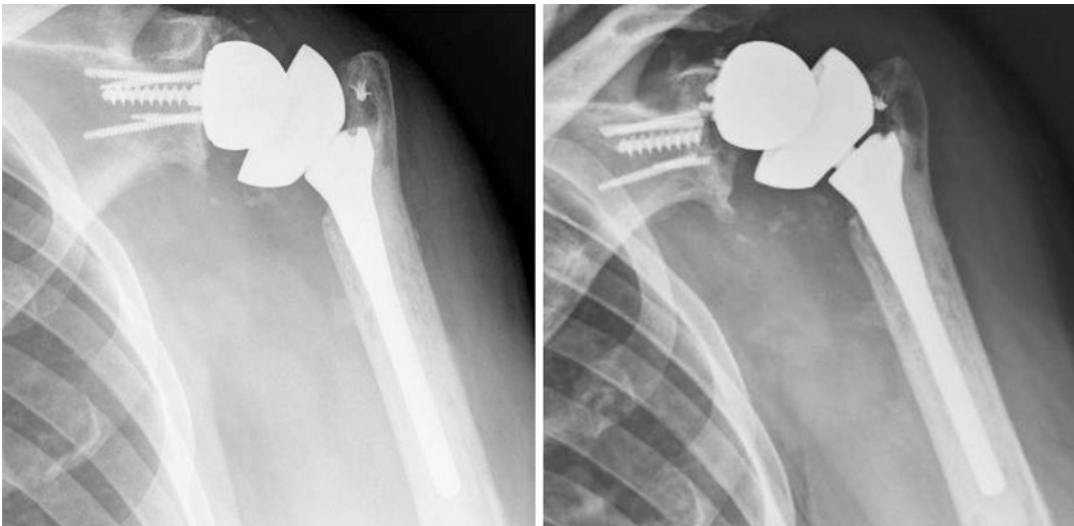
Pre- and post-failure radiographs taken at different time intervals reveal a gross difference in baseplate positioning with associated hardware failure indicating AGBL
